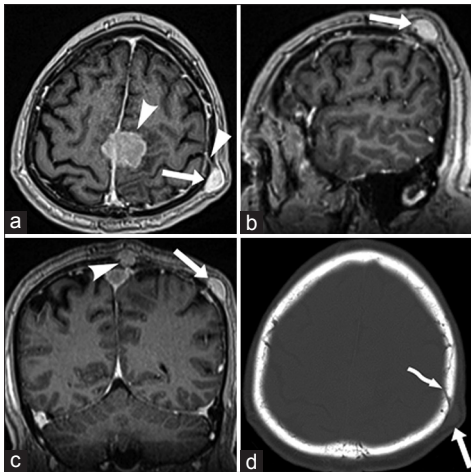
Preoperative magnetic resonance imaging with intravenously administered contrast (a-c) showed an inhomogeneously enhanced, intracranial mass (curved arrowhead) along with a subcutaneous nodule (arrow). The nodule appeared to be connected with the underlying meninges through contrast-enhanced tissue (arrowhead). Thickening of the underlying meninges was observed. Unenhanced computed tomography scan showed that the nodule was located just inferior to the craniotomy edge (curved arrow, d)
